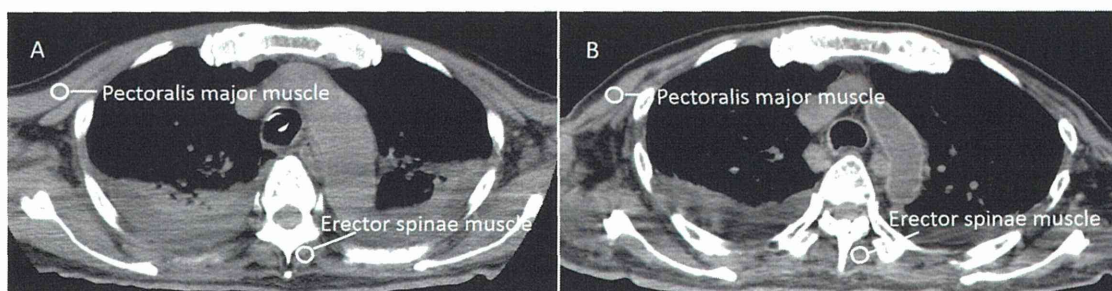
Antemortem and postmortem CT images of the pectoralis major muscle and the erector spinae muscle in a representative patient. A: Antemortem CT. B: Postmortem CT. Both images were obtained at the level of the aortic arch. PMM, pectoralis major muscle; ESM, erector spinae muscle.
